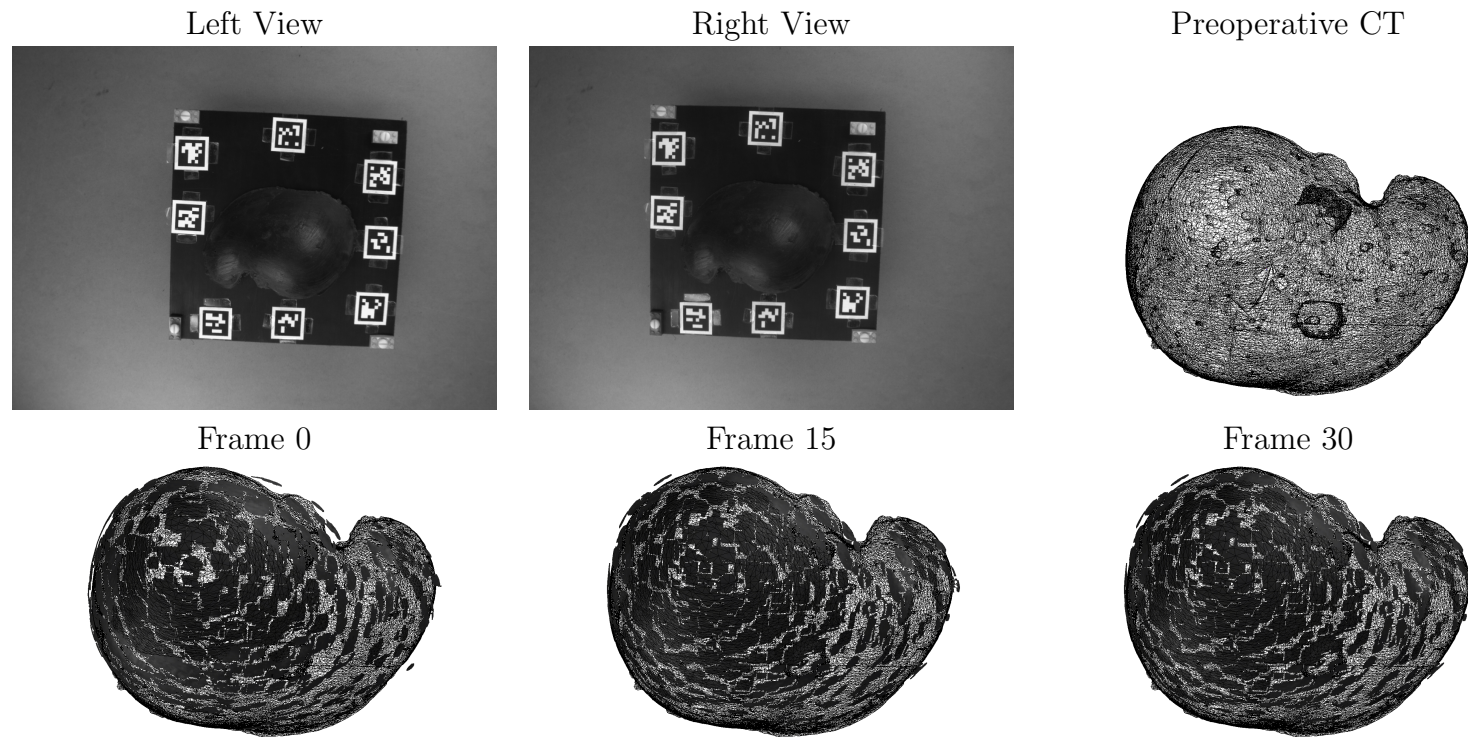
Qualitative Surface Registration Error (SRE) Results - Translation-Only. The left and right (non-rectified) views from the stereo camera are shown at the initial frame (frame 0). The preoperative *CT* scan is shown in a top-down view. The recovered stereo reconstructions (shown in darkest grey), registered to the preoperative *CT* scan, are shown at frames 0, 15, and 30.
